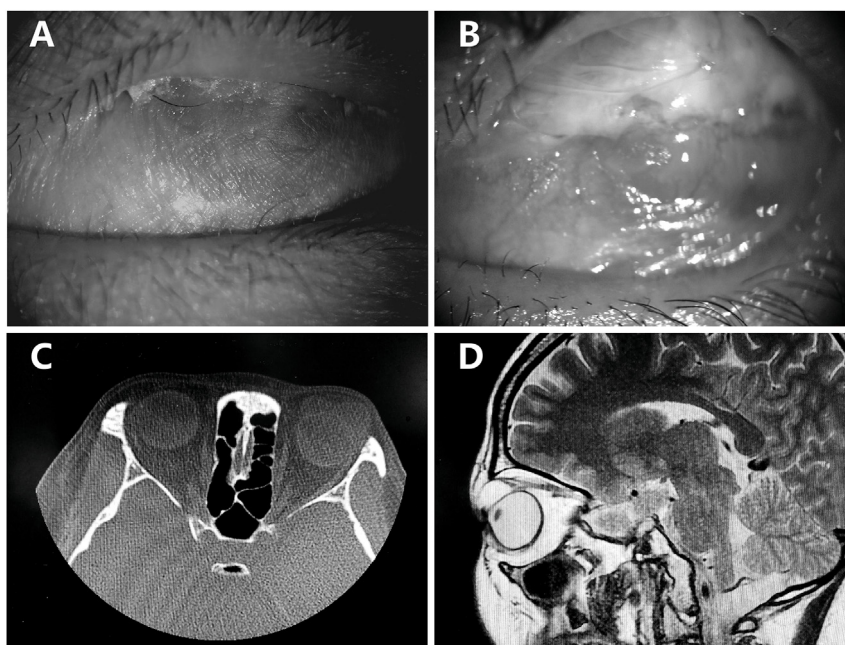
(A) The left eye of Case 4 with symblepharon and keratinization of corneo-conjunctival epithelium; (B) The left eye of case 4 a week after surgery; (C/D) CT showed two spherical occupying lesions above the left eyeball with a lower density.
